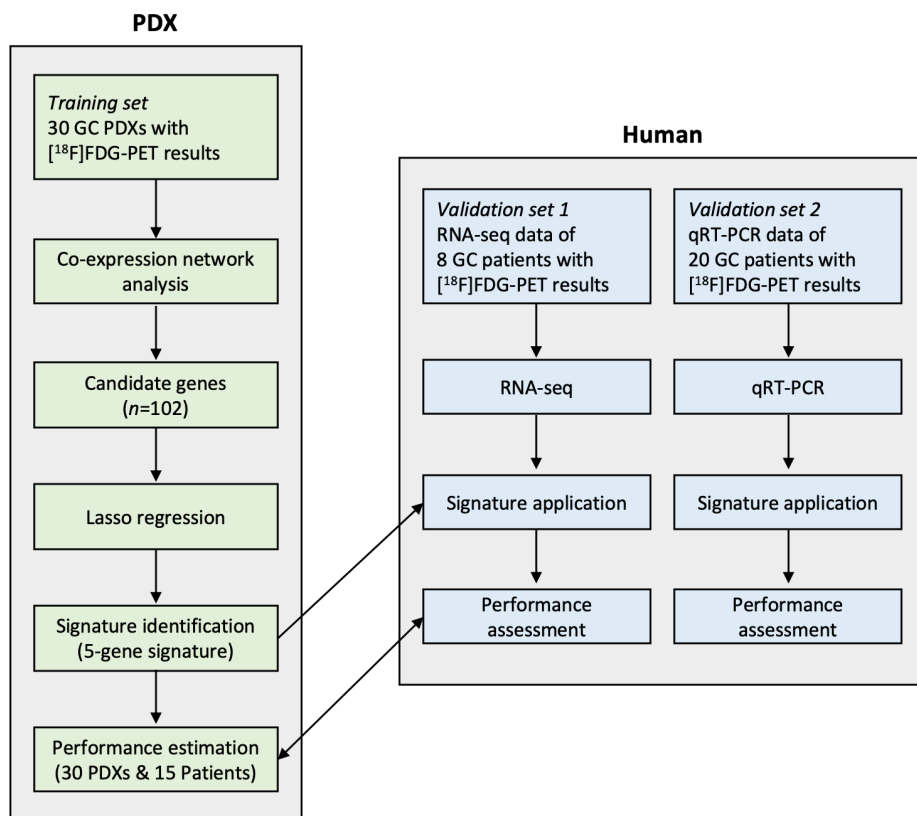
Study design. FDG-avidity prediction model is established investigating the gene expression profiles of thirty gastric cancer PDXs with [^{18}F]FDG-PET images. The model is then evaluated in human by RNA-seq and qRT-PCR with the gene signature.
